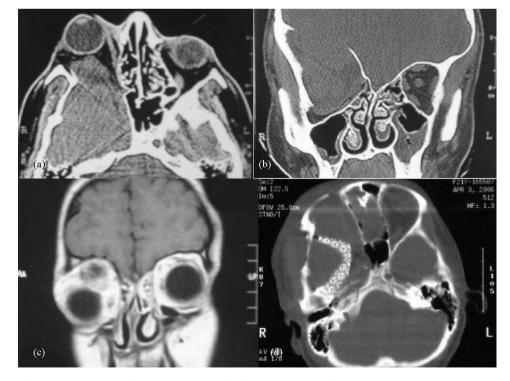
Case 1: (a) Axial CT of orbits showing absence of the right greater wing of sphenoid. The temporal lobe is herniating into the orbit pushing the eye forward. (b) Coronal head CT reveals right temporal lobe herniation into the orbit. The orbital floor is displaced downwards and the ethmoid bone is displaced medially. (c) Coronal MRI showing the severe downward and outward deviation of the eye. (d) Post-operative head CT scan showing the reconstruction of the posterior wall of the orbit and the greater wing of the sphenoid bone.
